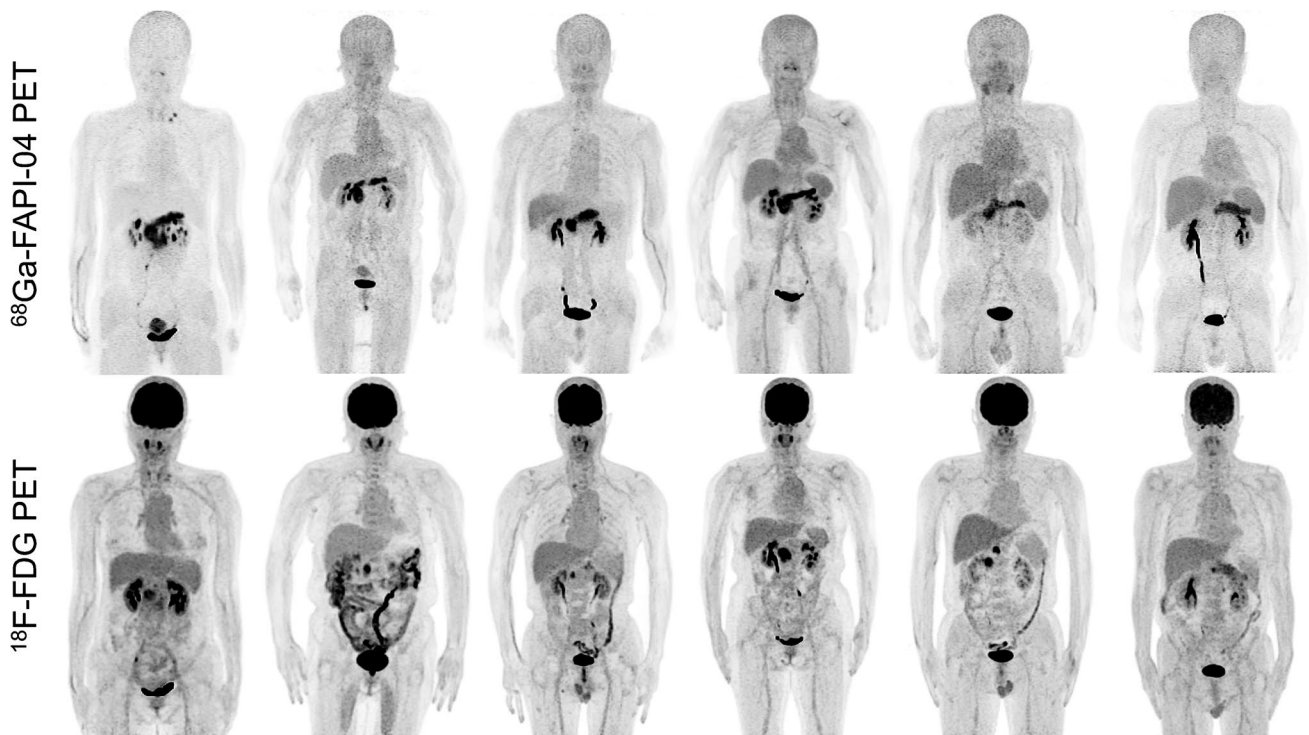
Representative maximum intensity project (MIP) images of ^{68}Ga -FAPI-04 PET and ^{18}F -FDG PET in patients with concomitant pancreatic obstructive inflammation (patient 3, 14, 17, 19, 24, and 28)
